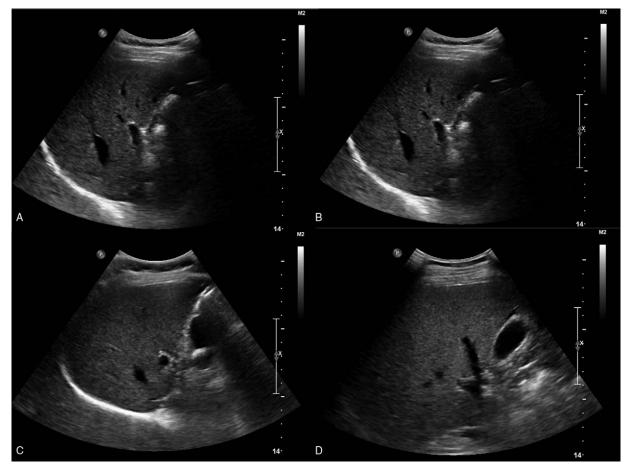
Fatty liver was graded according to sonographic findings. (A) Normal liver echogenicity; (B) mildly fatty liver with diffusedly increased liver echogenicity and appreciable periportal and diaphragmatic echogenicity; (C) moderately fatty liver with diffusely increased hepatic echogenicity obscuring periportal echogenicity, and diaphragmatic echogenicity is appreciable; (D) severely fatty liver in the diaphragmatic outline is obscure. Grade I: diffusely increased hepatic echogenicity, but diaphragmatic echogenicity. Grade II: diffusely increased hepatic echogenicity obscuring periportal echogenicity, but diaphragmatic echogenicity is still appreciable. Grade III: diffusely increased hepatic echogenicity obscuring periportal as well as diaphragmatic echogenicity.
